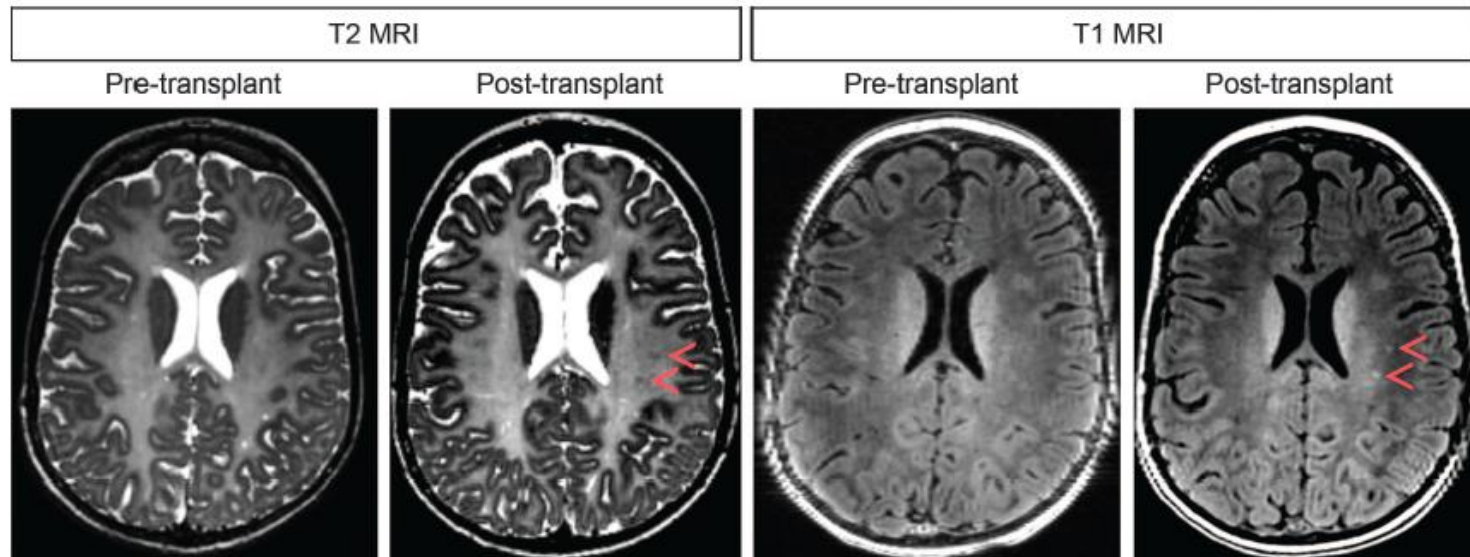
MRI images at baseline (pretransplant) and 12 months after transplant for subject 2. Small ovoid areas of T2 hypointensity and T1 hyperintensity (red arrowheads) were not present before transplantation and then gradually became visible after transplant. These areas do not represent small cysts because decreasing T2 hyperintensity is observed.
